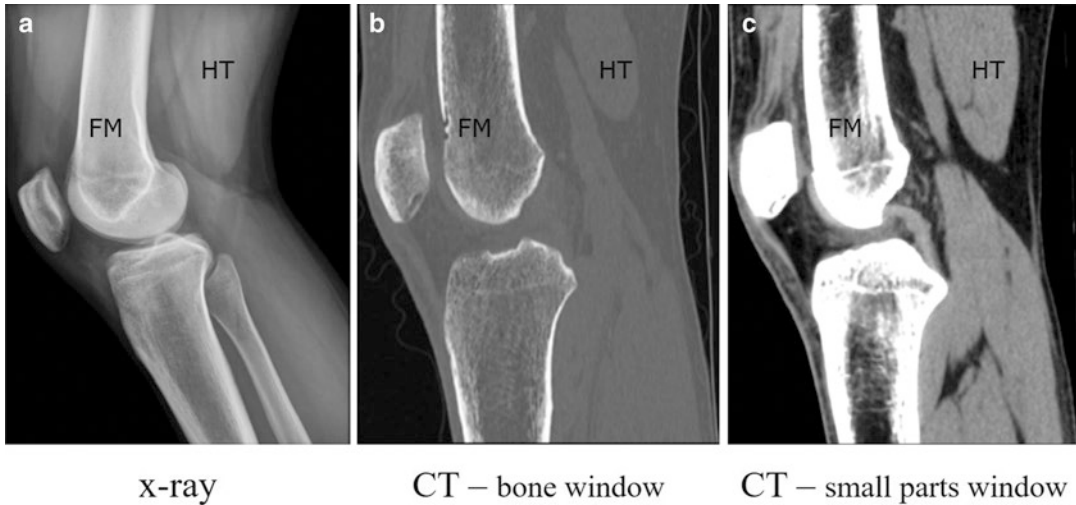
Knee. (a) Lateral X-ray; (b) CT sagittal reconstruction (bone window); (c) CT sagittal reconstruction (small parts window). *—Fat densities (infrapatellar fat
